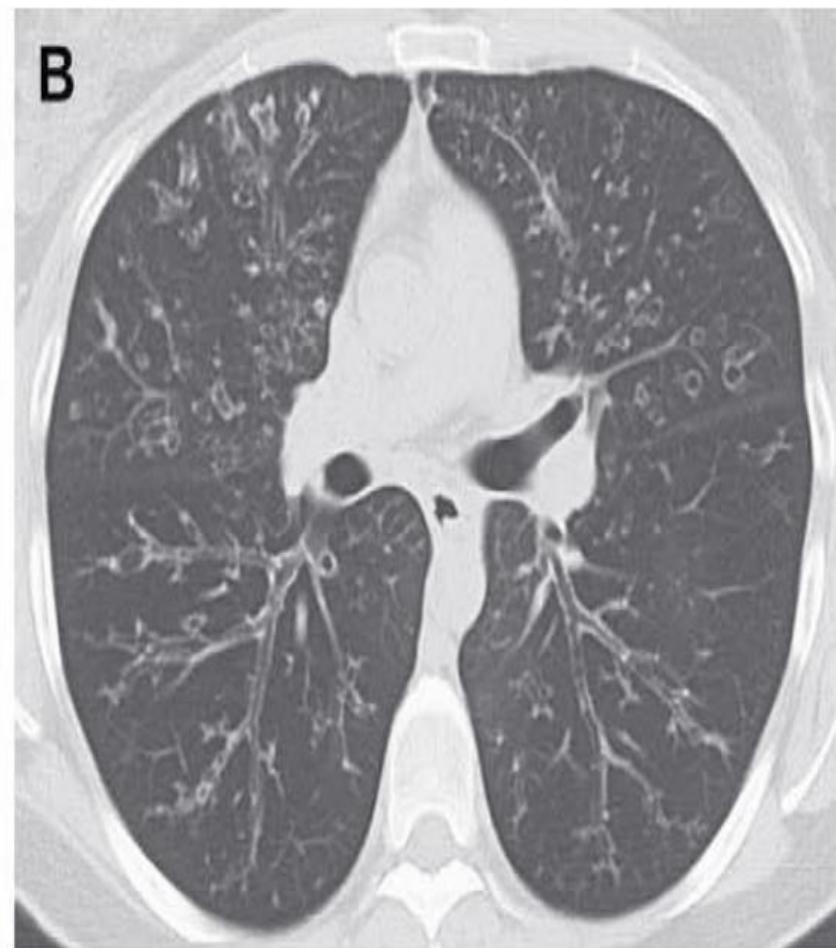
CT findings of diffuse bronchiectasis in a 27-year-old woman with cystic fibrosis. Transaxial images show the dilated bronchus and adjacent arteriole, seen along their short axis, creating the signet ring sign (arrow) (A). When the bronchi are visualized along their course, the lack of normal tapering and smooth bronchial wall thickening can be appreciated (B). In cystic fibrosis the fatty attenuation of the pancreas is indicative of the pancreatic insufficiency (C).
